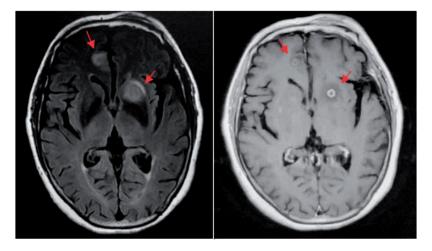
Head magnetic resonance imaging revealed multiple small round signals in both frontal/parietal lobes, indicative of brain abscess.
